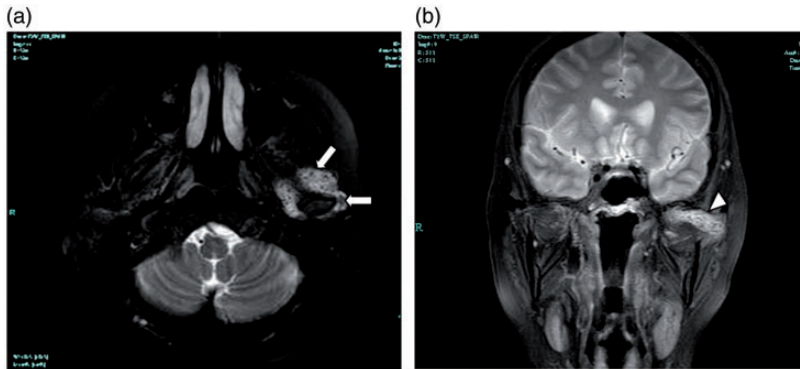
Magnetic resonance imaging (MRI) of the temporomandibular joint region showing the obviously expanded joint space. (a) Axial MRI revealing expansion of the anterior joint space (white arrow). (b) Coronal MRI showing the upper boundary of the mass (white arrowhead).
